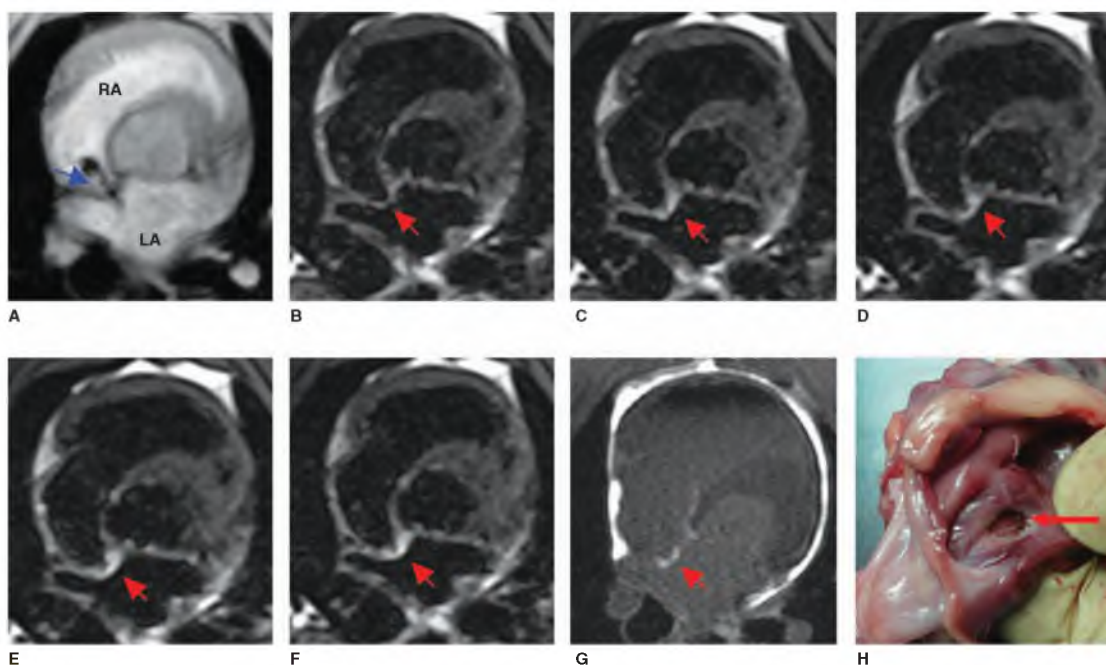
Detection of acute atrial lesion. A. Image from a three-dimensional scan to locate the catheter tip. B-F. T2-weighted dark blood images acquired before ablation (B) and after ablation at 20 seconds (C), 50 seconds (D), 2.5 minutes (E), and 8 minutes (F). G. Postmortem, high-resolution, delayed-enhancement magnetic resonance image. H. Photo of excised heart. Blue arrow indicates the position of the catheter tip at septal wall. Red arrows indicate the location where the lesion was created using a 30-second ablation with 30 W. LA, left atrium; RA, right atrium.
